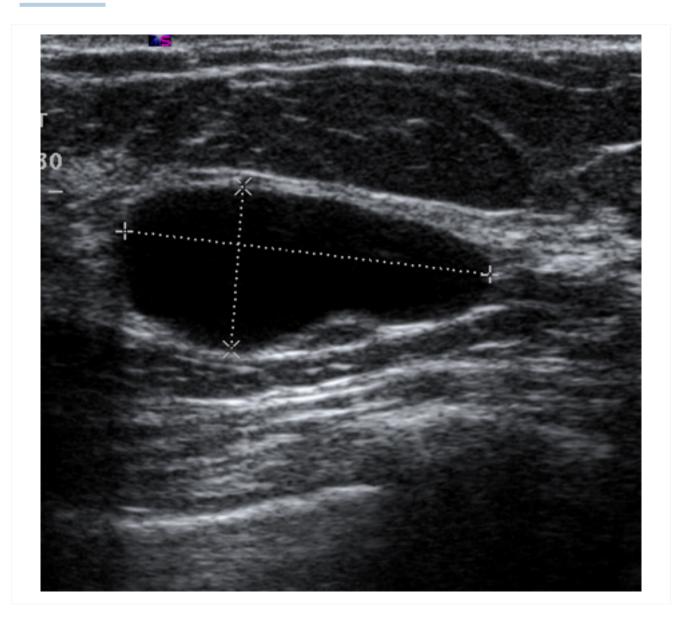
Ultrasonographic image of a simple cyst
